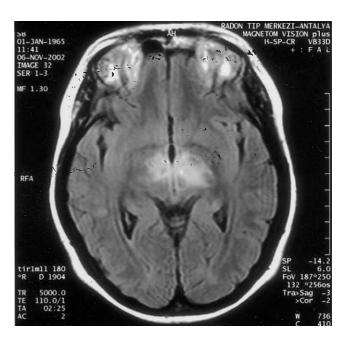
Fluid-attenuated inversion recovery (FLAIR) weighted transverse MR image shows hyperintense lesions in cerebral peduncles and subthalamic region.
